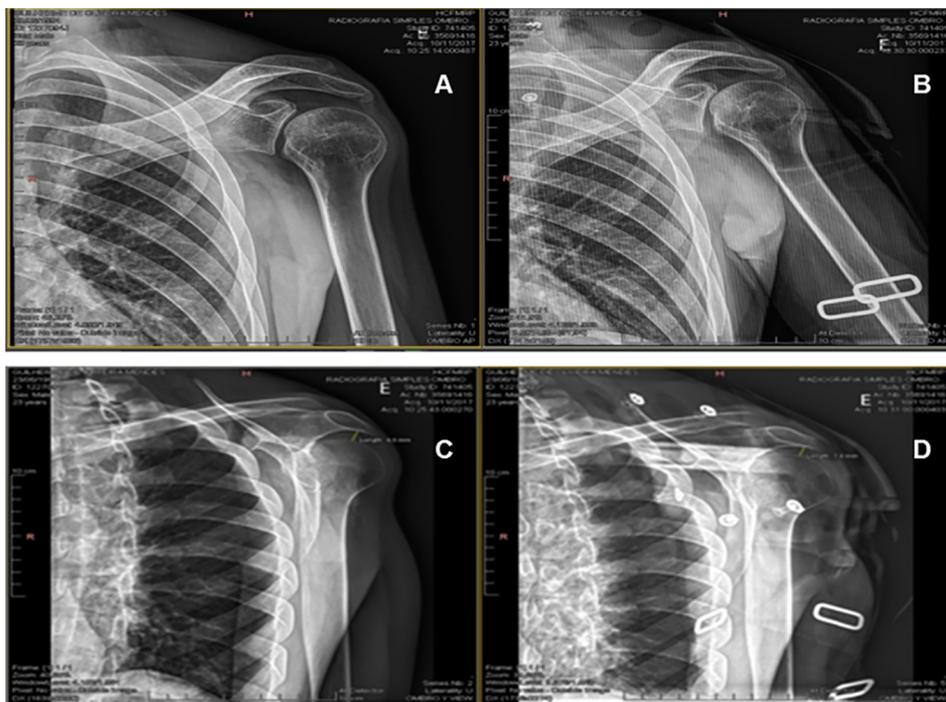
X-ray: (A) anterior view without the orthosis; (B) anterior view with the orthosis (C) lateral view without the orthosis; (D) lateral view with the orthosis.
